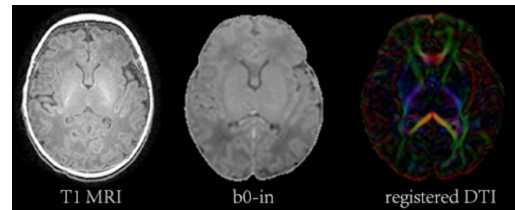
Registration results. The left two pictures show the T1 MRI and b0-in used in the registration process, and the third picture shows the registration results.
